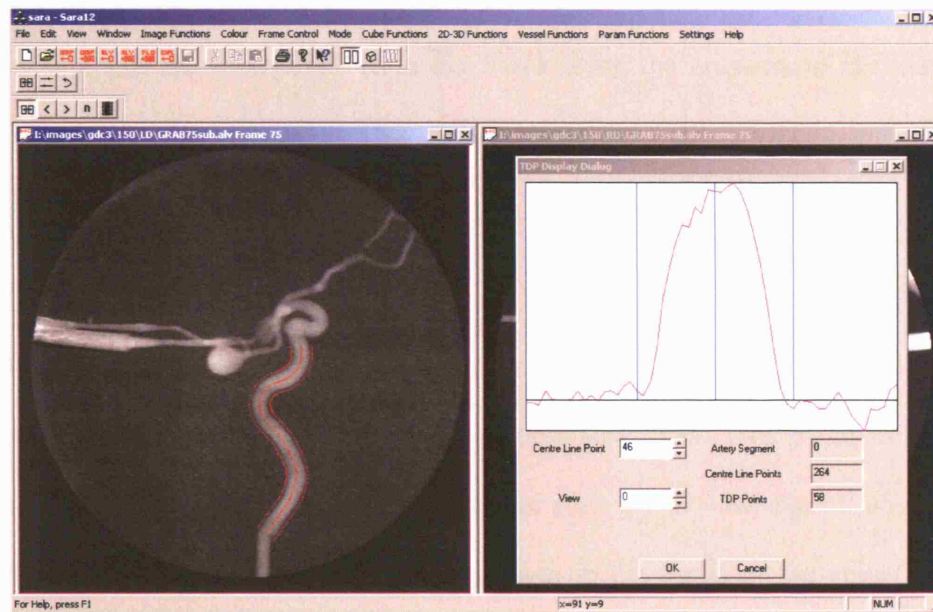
SARA 2000 software: Stage 3: 2D Vessel Centreline Determination: The refined centreline, shown as the middle red line on the x-ray image, is calculated using the centre of gravity of the TDP, an example of which is shown on the right.
